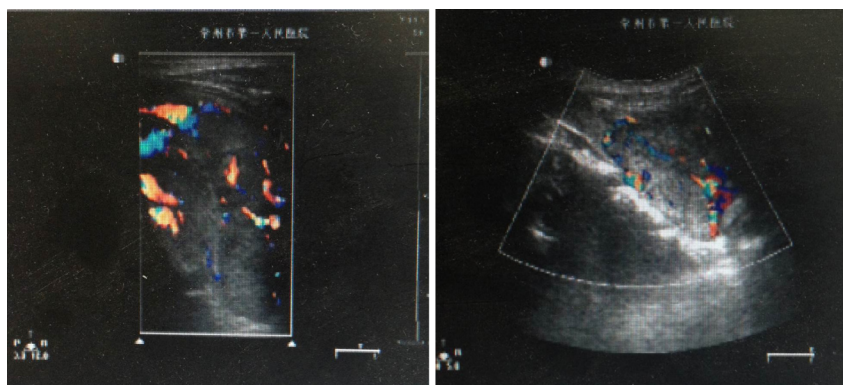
Ultrasonography of neck showed a 3.0 cm × 2.0 cm hypoechoic solid lesion posterior to right lobe of thyroid.
